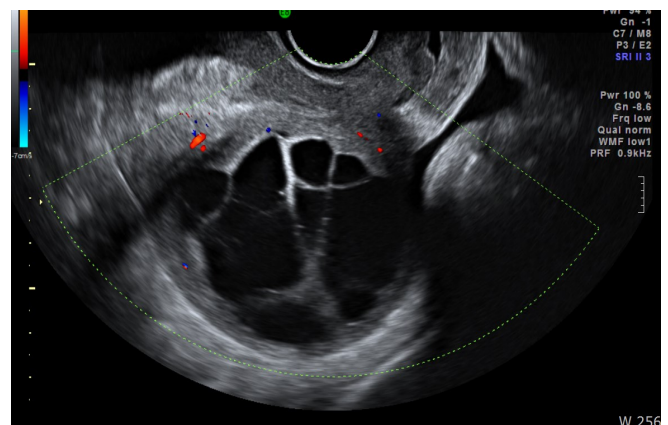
At posterior corpus of uterus, a 6.3×5.6-sized homogenous hypoechoic lesion is shown with multiseptated cystic degeneration on transvaginal ultrasonography.
